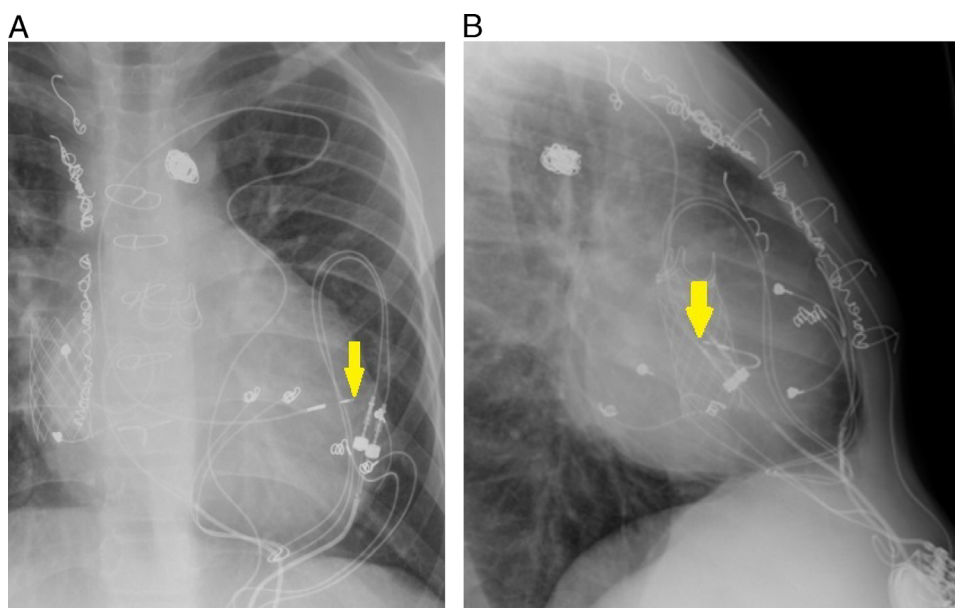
Chest radiographs of the pacing system with arrow showing the new transvenous ventricular pacing lead. A: Posteroanterior. B: Lateral.
